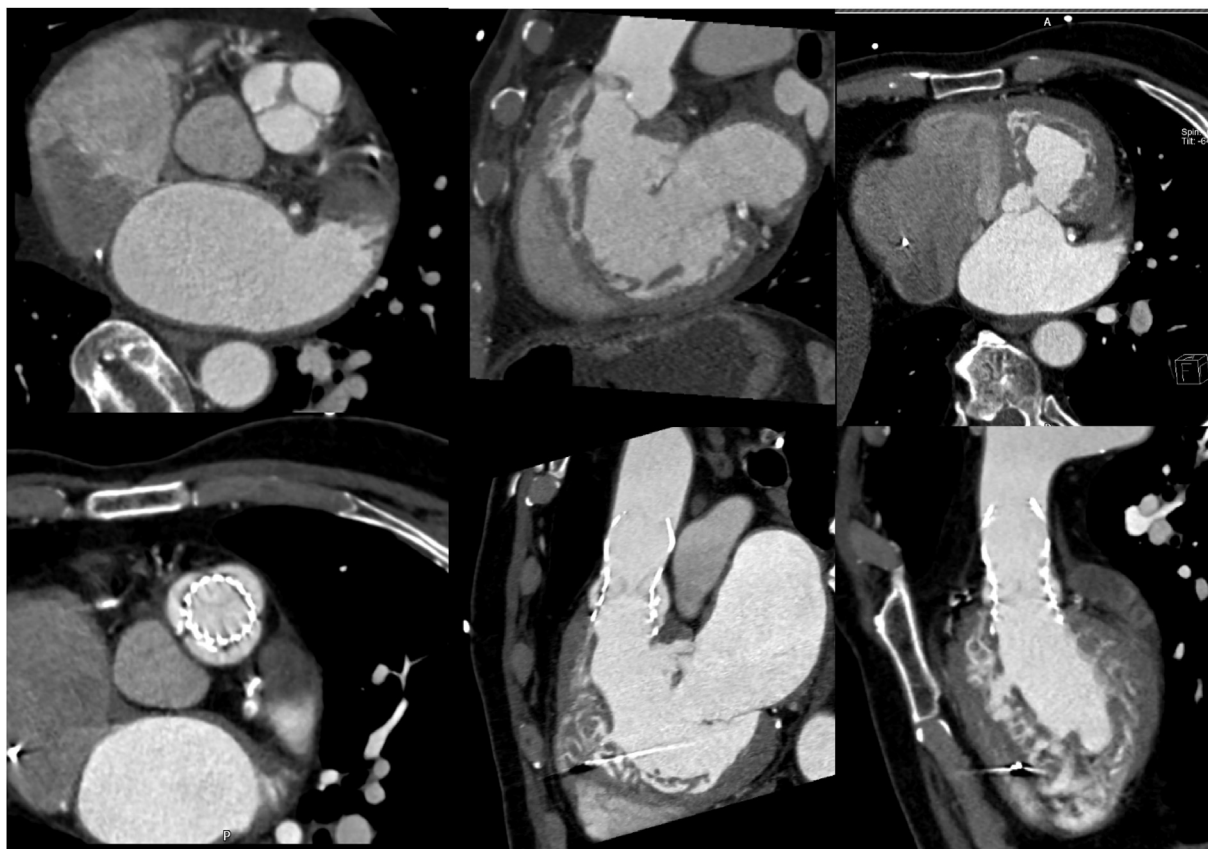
CT images pre and post-procedure in a patient with corrected TGA.
